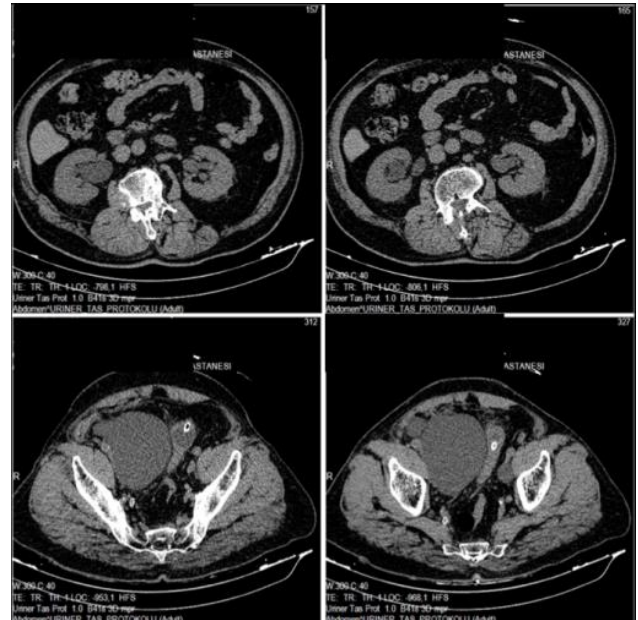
Bilateral grade II renal pelvicaliectasis and giant lymphocele in the non-contrast CT
